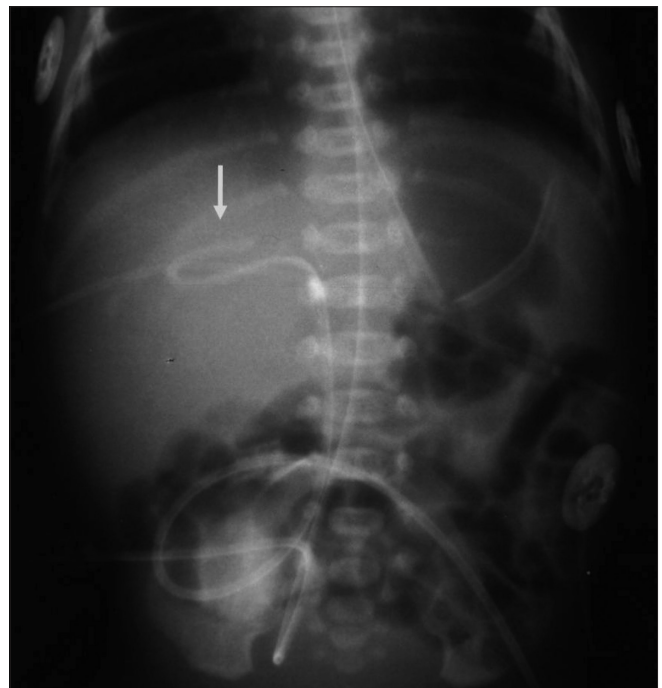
Frontal radiograph of the abdomen shows looping of an umbilical venous catheter in the liver (arrow) with its tip in the right branch of the portal vein
